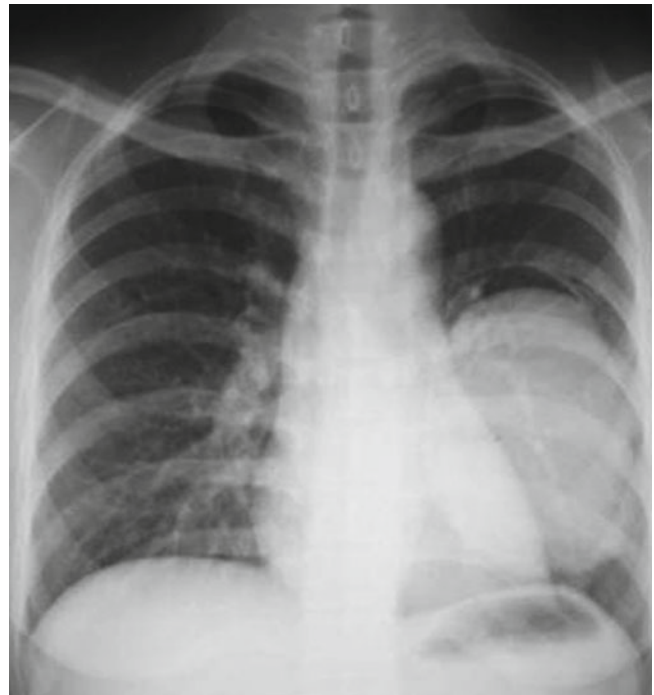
Pulmonary hydatid X-ray demonstrates round shaped lesion in the left lower lung with regular margin, well defined boundary, and even density
